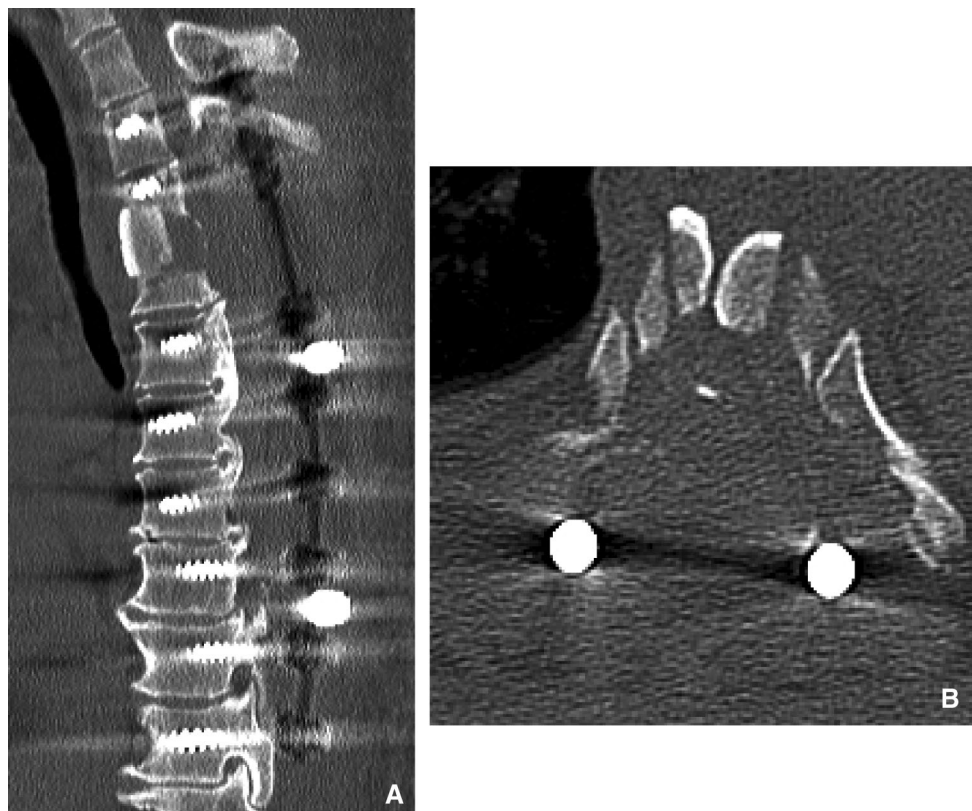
A 69-year-old woman with upper thoracic myelopathy (Case 2). CT sagittal image showed T3–7 mixed type OPLL. Beak shape type OPLL was seen at T3–4 level (a). The maximum occupancy ratio of OPLL against the spinal canal was 86.1 % at T3–4 level (b)
